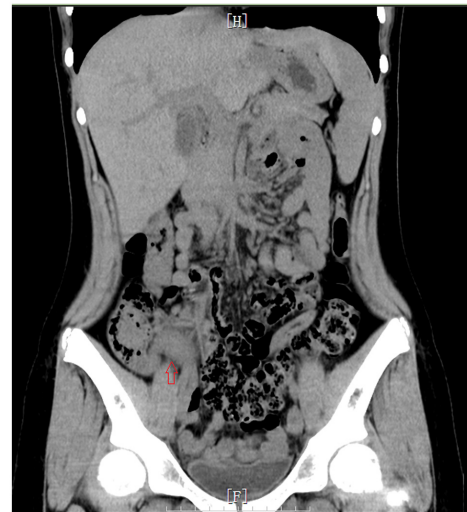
Computerized tomography (CT) scanning showing that the appendix is thickened with exudation, as indicated by the arrow.
